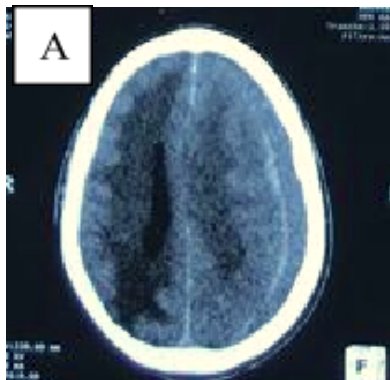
Cerebral CT scan without contrast injection showing a left hemispheric chronic subdural hematoma.
